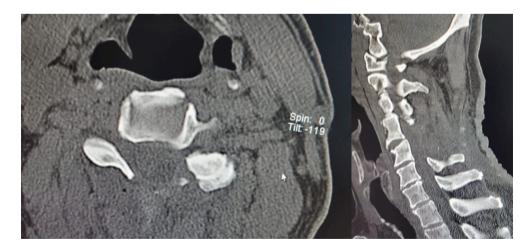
Showing postoperative CT scans, sagittal and horizontal views of the cervical spine, confirming the laminectomy and total removal of the bony structure.
